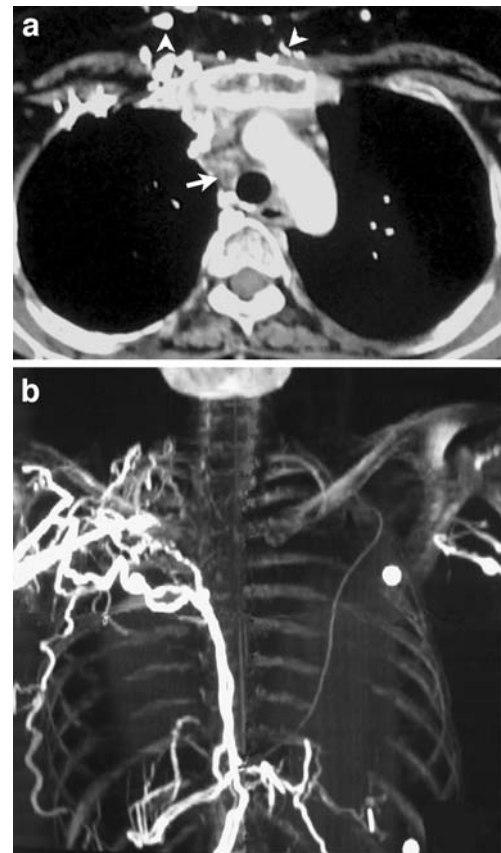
A 33-year-old woman with myogenic form of CIPO related to mitochondrial cytopathy who had had subtotal colectomy and jejunocolic shunt 4 years ago. The patient was referred for intravenous nutritional therapy. a Axial MDCT of the thorax shows superior vena cava thrombosis (arrow) and numerous cavocaval pathways (arrowheads). b CT reformation using maximum intensity projection better shows the complex venous network
